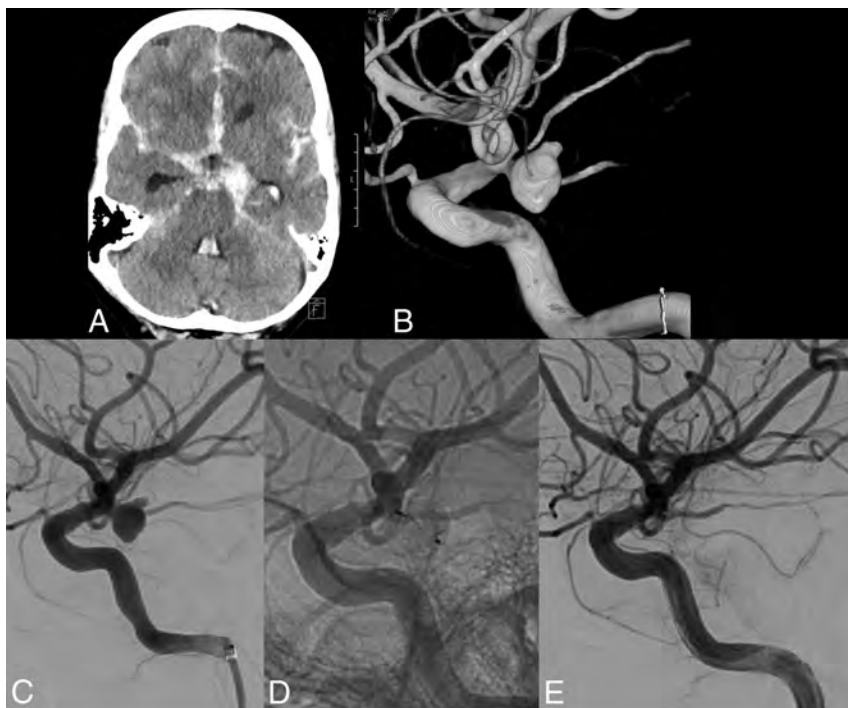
A 60-year-old woman with a ruptured small-neck posterior communicating artery aneurysm. A, CT scan shows subarachnoid hemorrhage. B, 3D angiogram reveals a 6-mm posterior communicating artery aneurysm with a small neck. Angiogram before (C) and after (D and E) placement of a 6-mm WEB-SLS shows complete aneurysm occlusion.
